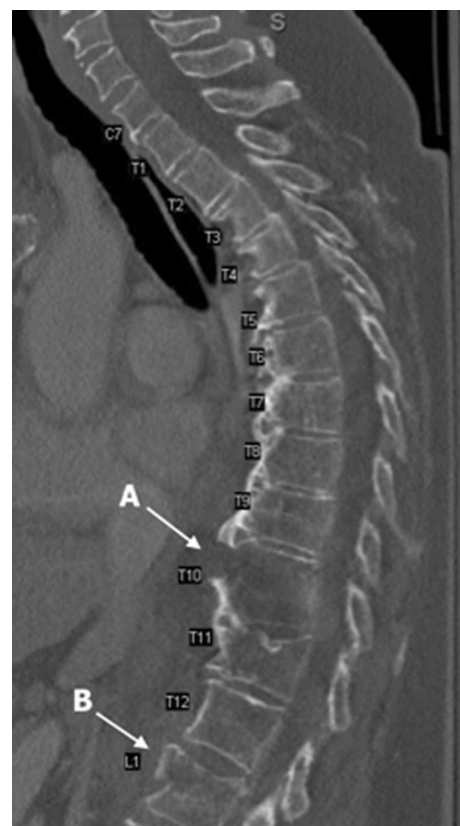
Preoperative sagittal CT of the thoracic spine showing (a) an unstable Chance fracture through the superior T10 vertebral body involving the anterior and middle columns, and (b) an unstable two column burst fracture of the L1 vertebral body
